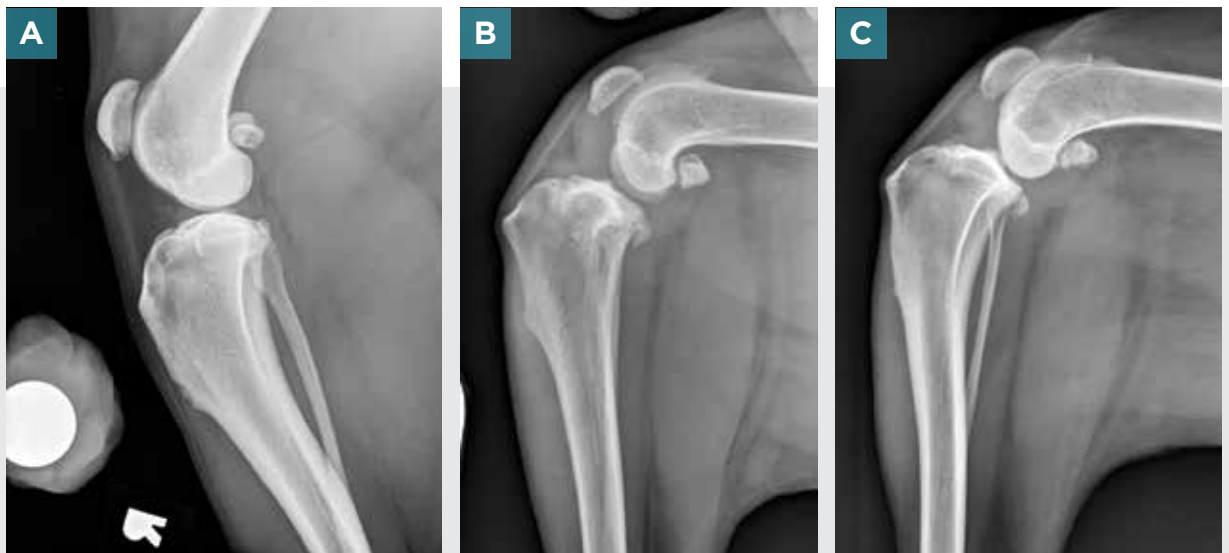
Stifle radiographs. (A) Normal stifle. (B AND C) Deficient cranial cruciate ligament with increased effusion, osteophytes, and cranial tibial subluxation.
